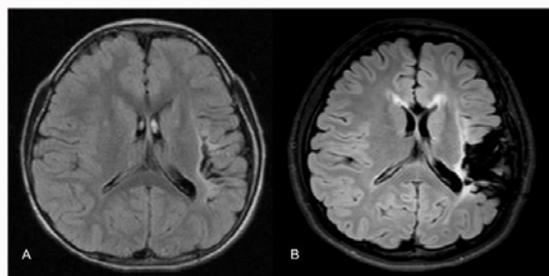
A) At 5 years of age, axial FLAIR MRI showing a high-intensity lesion in the area surrounding the left Sylvian area. B) At 15 years of age, postoperative axial FLAIR MRI revealing dissected anterior corpus callosum and temporal lobe. Glial scars are observed as high-intensity lesions surrounding the dissected area.
